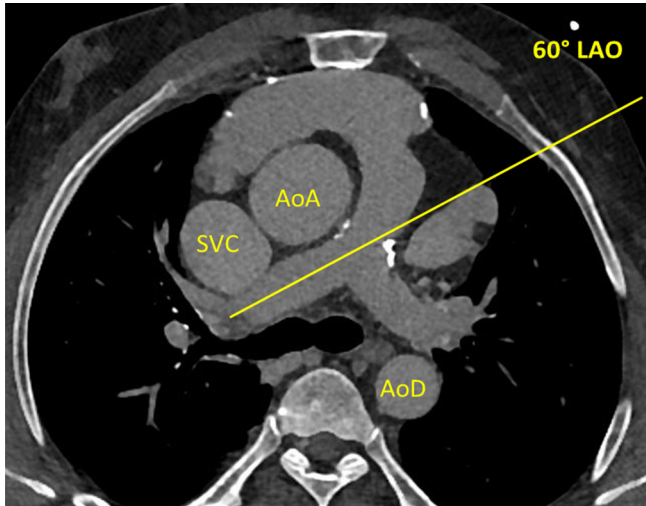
Transverse plane of a CT-scan (Patient 1). The angle of the RPA long axis is determined to 60° LAO (yellow line). This angle serves as orientation for the lateral fluoroscopy plane to guide the needle puncture from the SVC to the RPA. RPA, right pulmonary artery; LAO, left anterior oblique; SVC, superior vena cava [Color figure can be viewed at wileyonlinelibrary.com]
